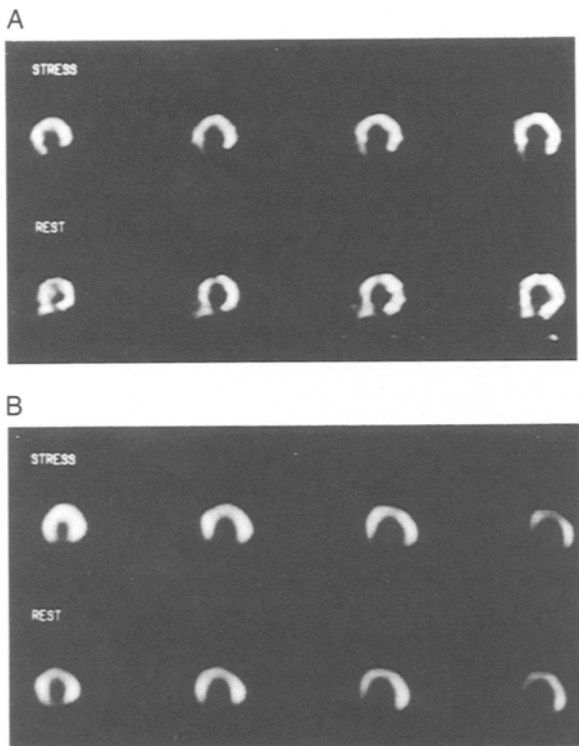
Reconstructed short-axis rubidium-82 PET (A) and thallium-201 SPECT (B) images in a patient with significant coronary artery stenosis and previous myocardial infarction. Please see text for explanation.
